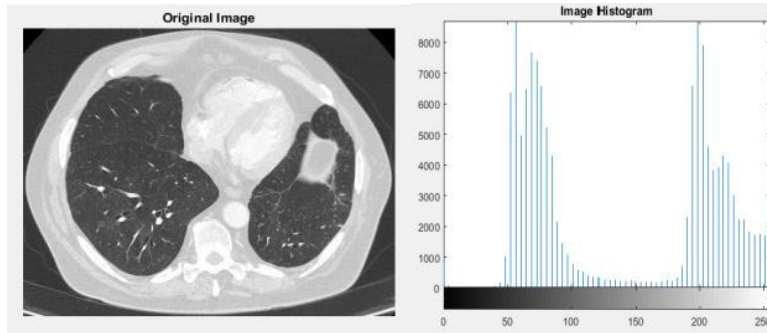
CT scan of a malignant lungs and its histogram
